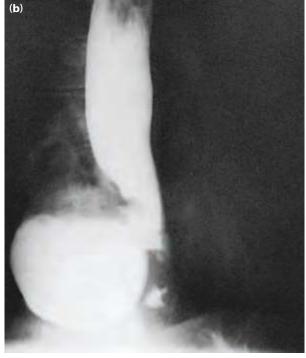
Epiphrenic diverticulum proximal to the gastrooesophageal sphincter. (a) Small and asymptomatic; (b) large, symptomatic and appearing as a gas-filled bubble on the chest radiograph.
